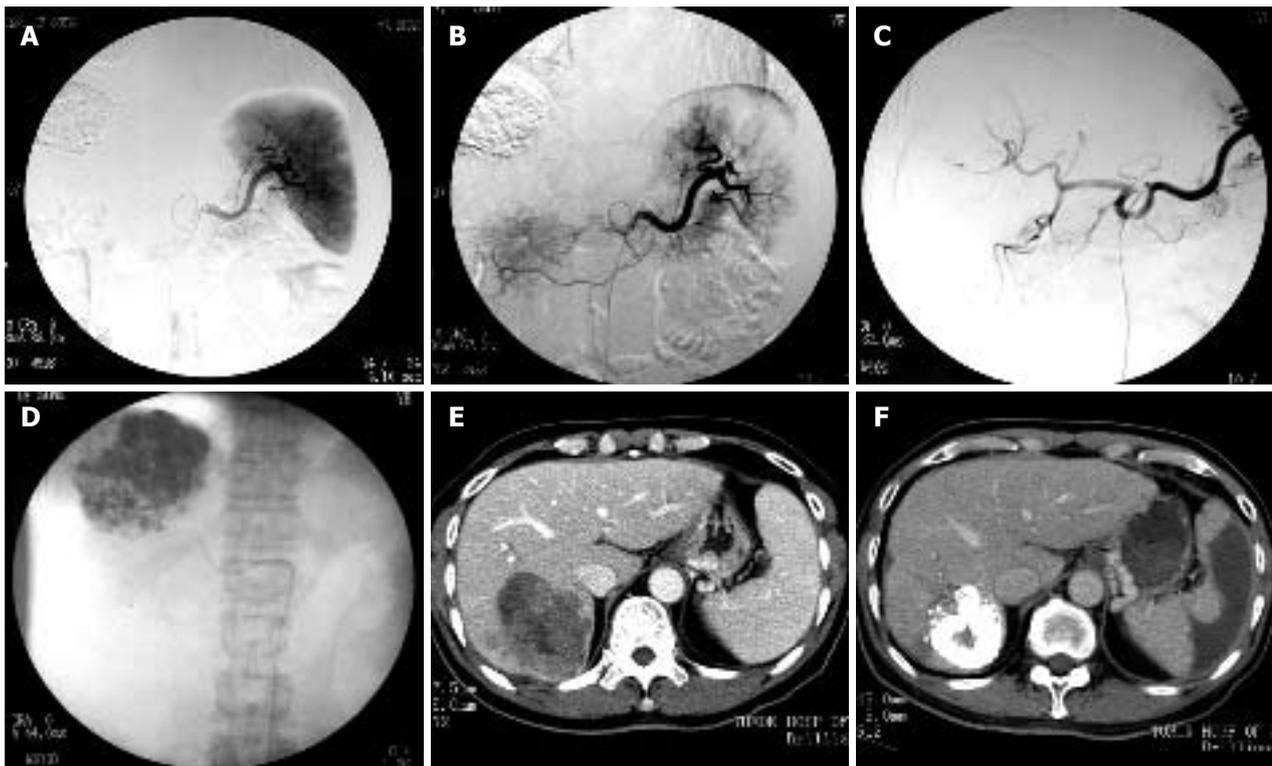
PSE treatment for a 68-year-old male case of HCC with splenomegaly and thrombocytopenia. A: Splenic arteriography before PSE showing the whole splenic parenchymal image; B: Splenic arteriography after PSE showing the residual splenic parenchymal image, part of the peripheral splenic parenchyma was ablated, and the extent of embolization was roughly estimated of approximately 60%; C: Celiac arteriography before TACE showing the tumor blood-supply image; D: TACE is terminated when the tumor is filled with emulsifier; E: Transverse CT image revealing splenomegaly at 1 wk before PSE/TACE; F: Transverse CT image revealing the infarction of peripheral splenic parenchyma at 2 wk after PSE. The extent of embolization was 62% calculated by CT volume analysis software.
